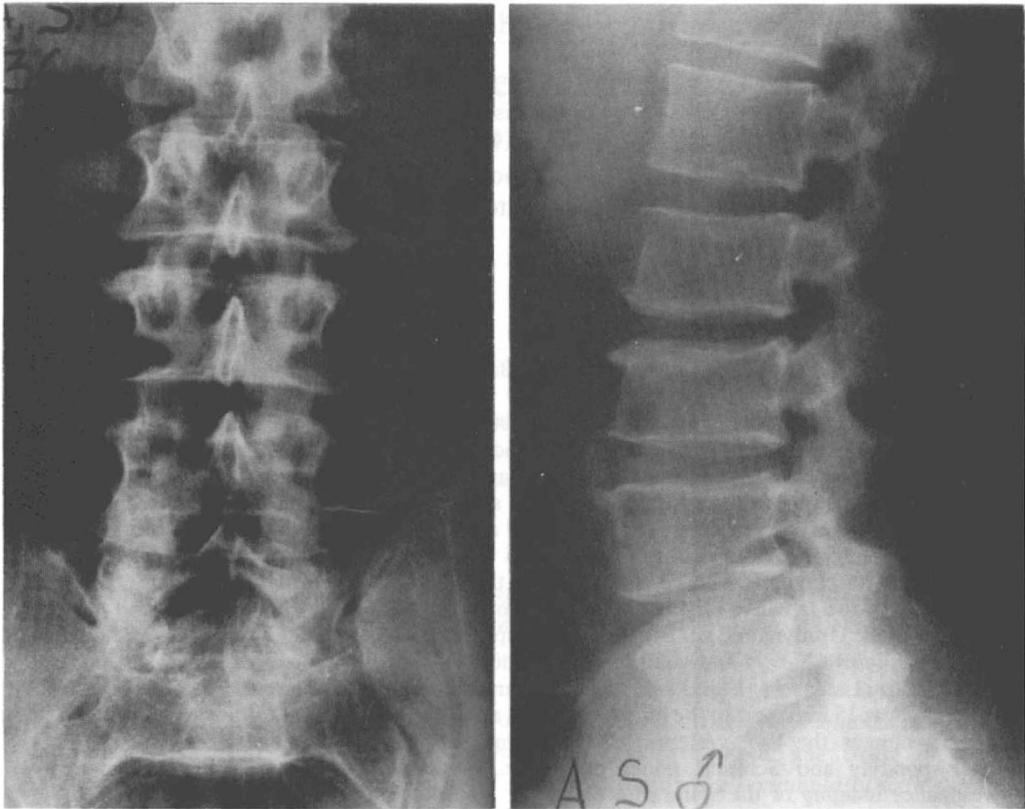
Lumbar spine X-rays demonstrating spinal canal stenosis.
